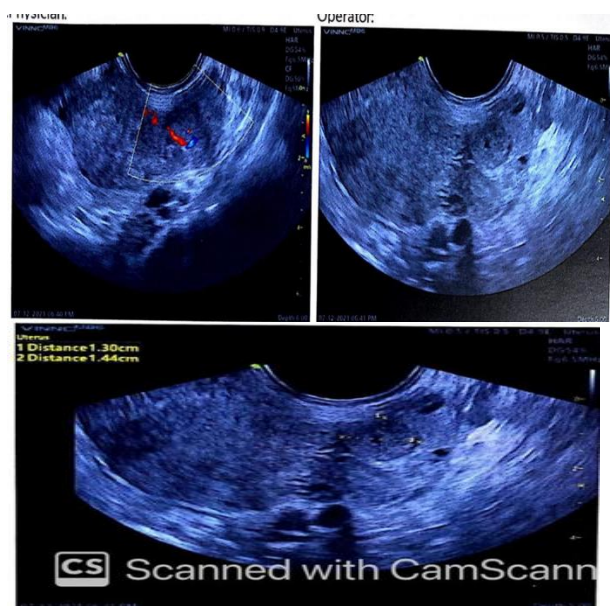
Ultrasound report of cesarean scar pregnancy for confirmation.
